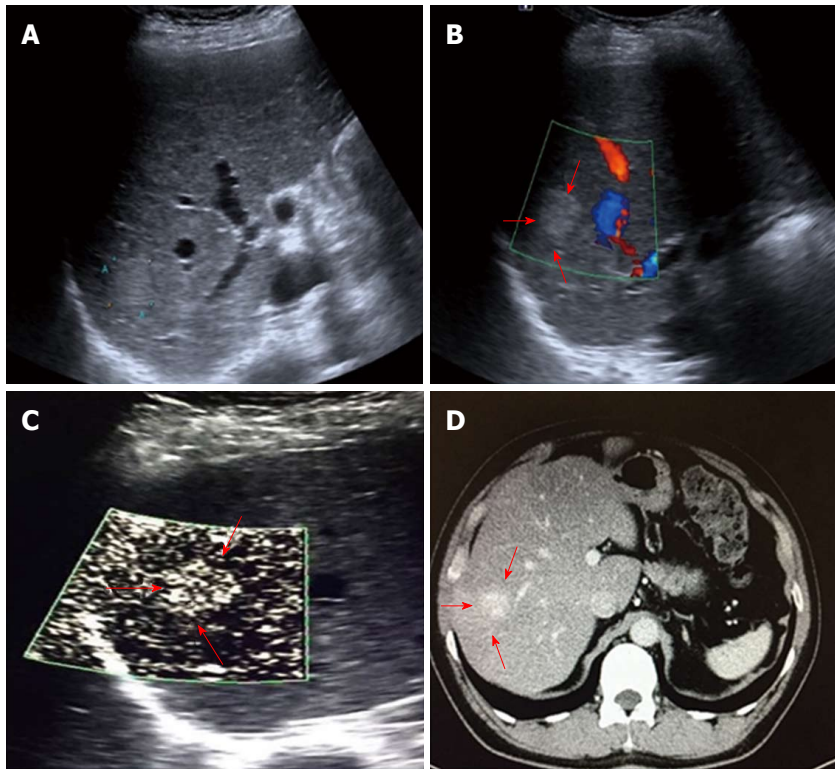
Diffuse dot-like type (type I) in a 52-year-old male diagnosed with hemangioma. A: A high-echo lesion with a clear margin was evident in the right liver lobe; B: CDFI showed no blood flow signals for this lesion; C: SMI showed a diffuse dot-like microvascular structure; D: Contrast-enhanced CT showed diffuse enhancement of the lesion in the arterial phase. SMI: Superb microvascular imaging.
